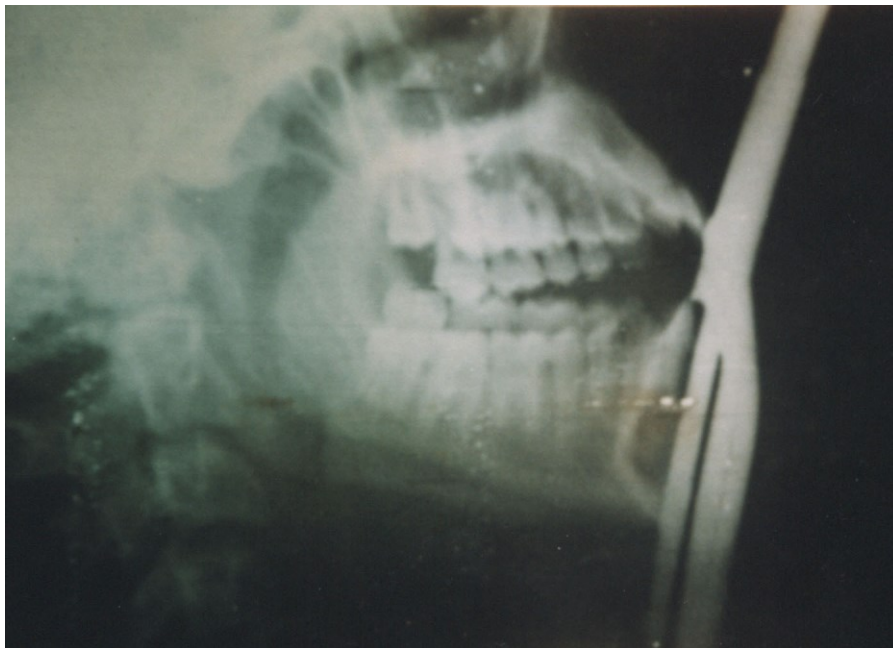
lateral radiograph showing the location of fish harpoon.
